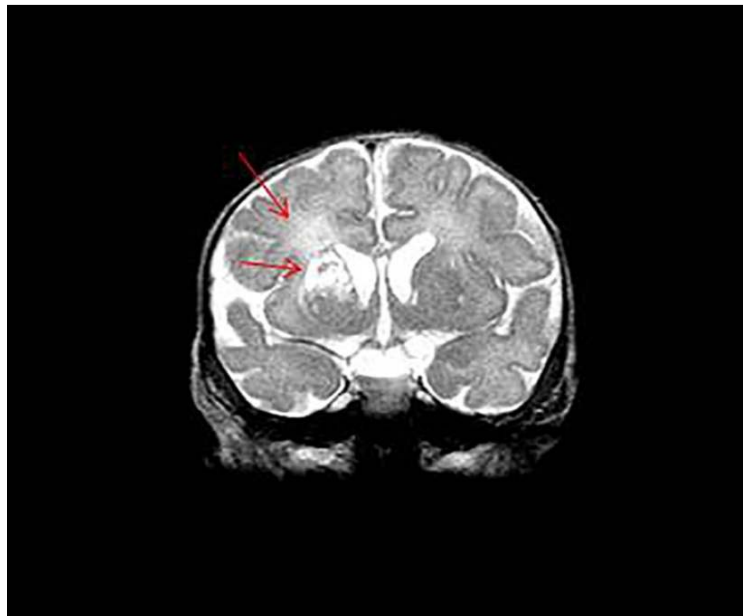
Brain MRI: (From the infants Above): Demonstrated bilateral periventricular cyst formation, mainly on the right side of the caudate head and putamen, which represented brain abscess
